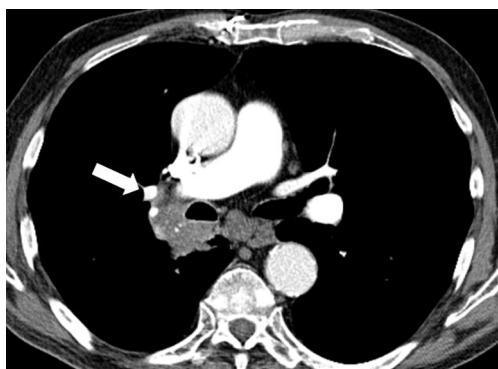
Preoperative chest CT scan. The white arrow indicates the tumour compressing the right main bronchus.
